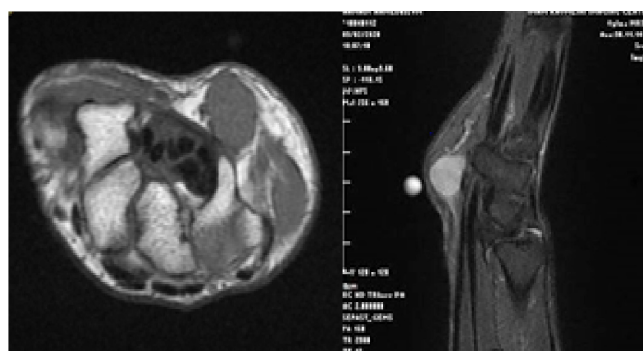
A hyper-signal mass presented in the Magnetic Resonance Imaging.
